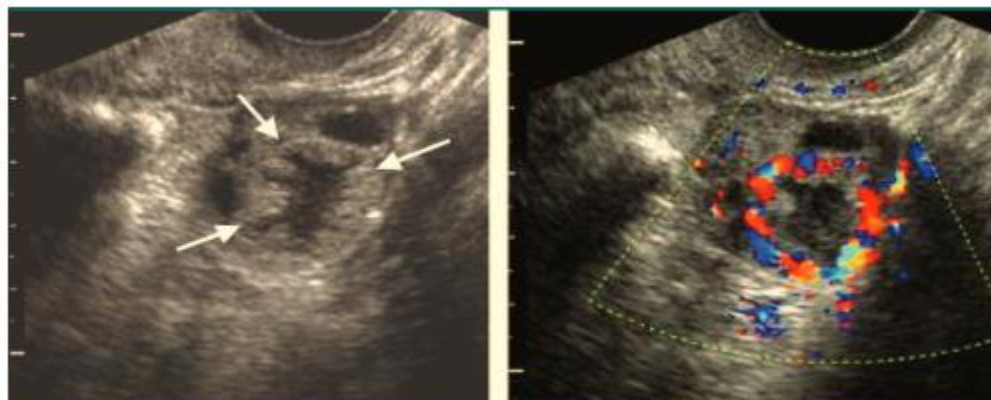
Corpus luteum in a 35-year-old woman. (a) Transvaginal US scan demonstrates a typical appearance of a corpus luteum within the ovary. It has a slightly thick, crenulated wall (arrows) and a small cystic center. (b) Color Doppler US scan shows abundant flow in the wall of the corpus luteum (9).
